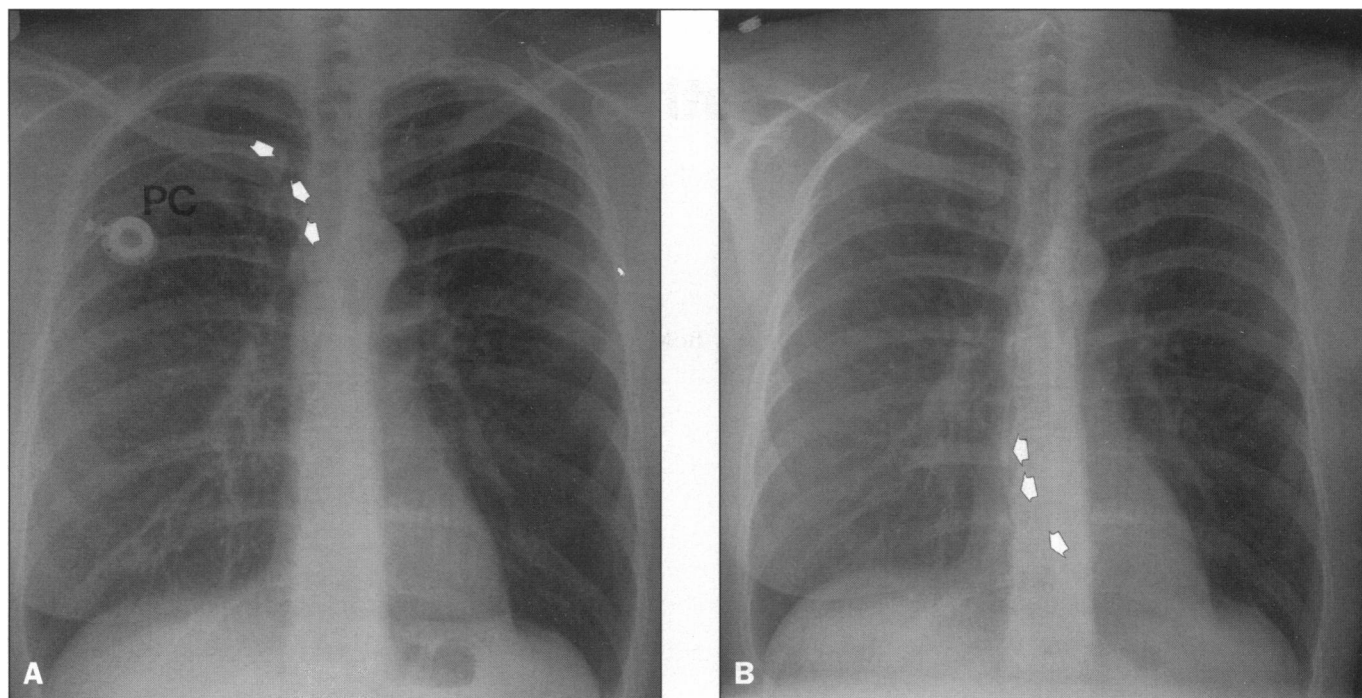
Chest radiograph demonstrating a port-a-cath (PC) infusion system inserted via the right subclavian vein. The reservoir is placed at the right infraclavicular region and the tip of the catheter is seen at the level of the superior vena cava (arrows). B. A control X-ray revealed migration of the catheter from the right subclavian vein into the right atrium and lodged in the right ventricle (arrows).
